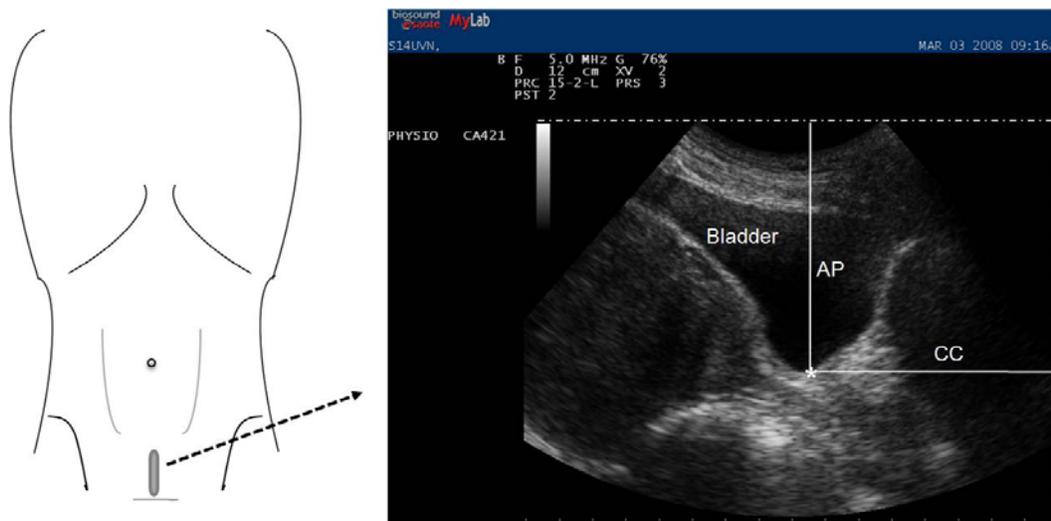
A. Sagittal supra-pubic (SSP) imaging site. B. Sagittal ultrasound image of the bladder and bladder base (*) showing the perpendicular anterior / posterior (AP) distance, and the cranial / caudal (CC) distance from the top of the USI image and the side of the USI image respectively to a reference point (* ; the most inferior border of the bladder) on the bladder base.
